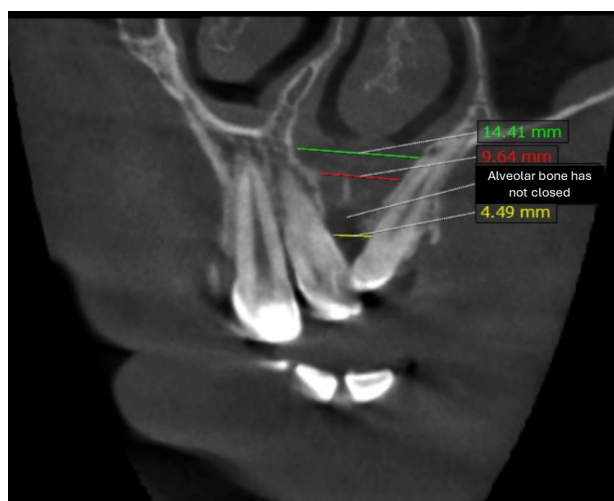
Coronal CBCT examination shows the size of the bone defect and the location of the teeth in relation to the CLP
